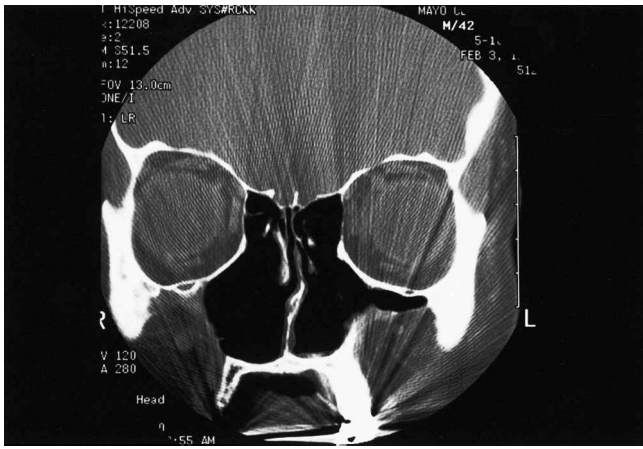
Coronal CT scan of a patient with atrophic rhinitis showing common findings of the “empty nose syndrome.” There is cavernous expansion of the intranasal airway with absence of the lateral nasal walls and inferior turbinates. The mucosa covering the middle turbinate remnants and paranasal sinuses is atrophied in this patient who had undergone four previous sinonasal surgeries for chronic sinusitis.
